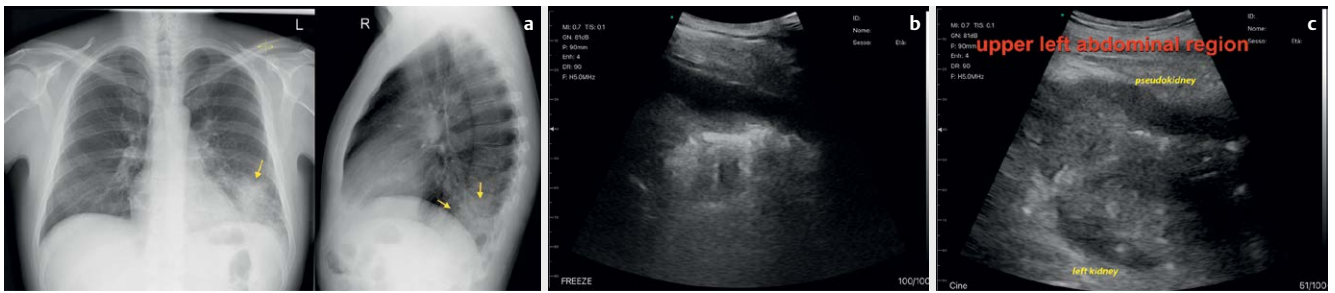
A case of incidental diagnosis: 64-year-old male; for a few days he has had fever and stinging pain in the left pulmonary base, with a sense of weight in the left side. In the emergency department, blood chemistry tests revealed microcytic anemia and high inflammation indexes. Chest X-ray (a) demonstrates pneumonia at the base of the left lung. Upon entering the ward, after the visit, he undergoes thoracic and abdominal ultrasound. BED MED-US confirmed left basal pneumonia (b) but diagnosed an unexpected expansive lesion of the colonic splenic flexure (c), such as colon cancer at that site, later confirmed by colonoscopy.
